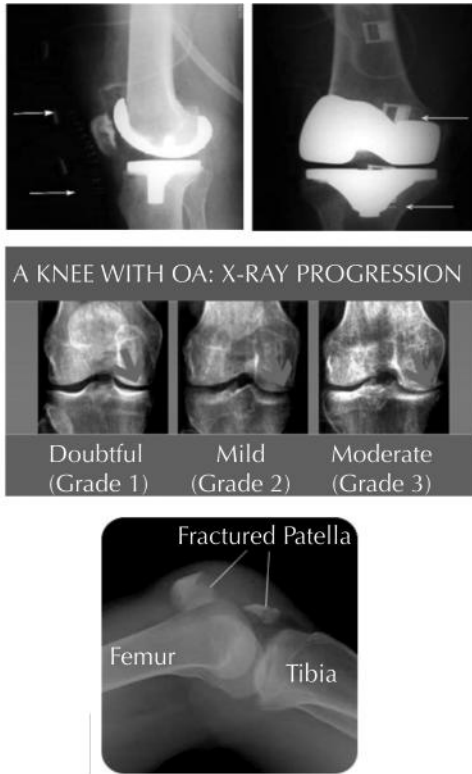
X-ray of the injured knee.
